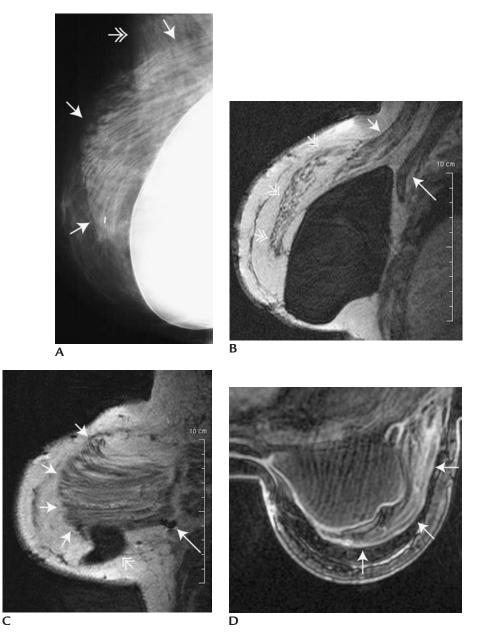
Patient with history of right mastectomy with implant and latissimus dorsi flap reconstruction. (A) Mediolateral oblique view demonstrating saline implant and latissimus dorsi muscle flap (*arrows*) with characteristic fatty striations superolateral to the implant. Pectoral muscle (*double headed arrow*) is also imaged. (B) Sagittal T1-weighted image of right mastectomy site demonstrates implant between pectoralis major (*short arrow*) and minor (*longer arrow*) muscles. Latissimus dorsi muscle flap (*double headed arrows*) can be seen more anteriorly overlying implant. (C) Sagittal T1-weighted image of right mastectomy site more laterally demonstrates striations of latissimus dorsi muscle flap (*arrows*) and small portion of implant (*double headed arrow*) inferiorly. Bloom artifact (*long arrow*) from a metallic clip is also apparent. (D) Axial, T1-weighted image with fat suppression demonstrates latissimus dorsi muscle flap partially overlying implant laterally. In reviewing breast MRs, it is always helpful to have a recent mammogram (and breast ultrasounds, if any are available) and relevant clinical and surgical history, as well as any breast pathology reports.
